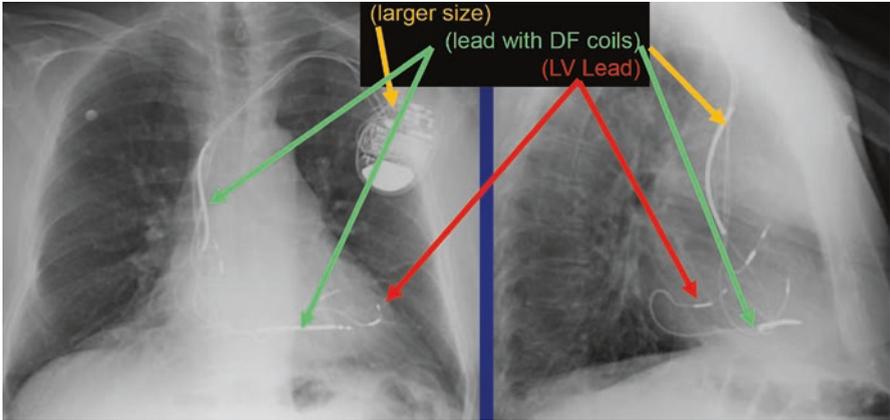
Anterior posterior and lateral chest x-ray showing a BiV ICD
